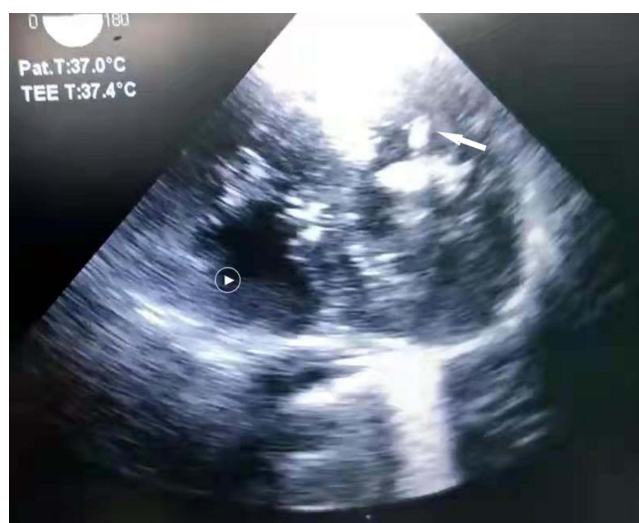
A medium echoic mass revealed by echocardiography.
